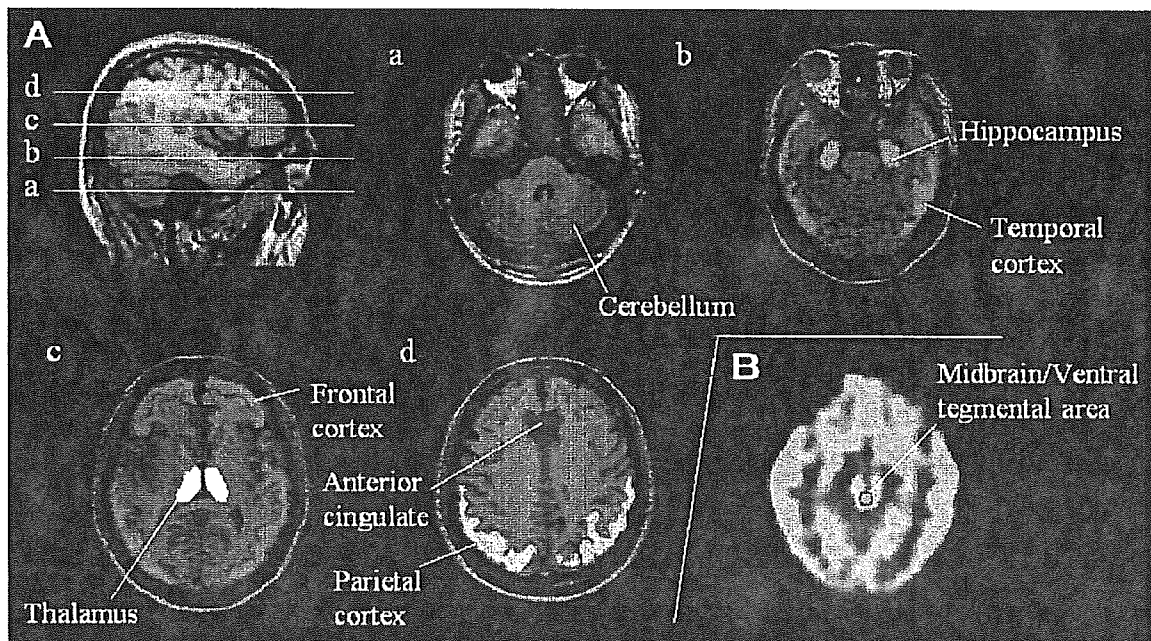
(a) The transformed VOI template placed on the axial slices of an MRI of one subject after refining to a segmented gray matter image. The horizontal lines through the sagittal section indicate the point of intersection for each of the corresponding axial sections. (b) The manually delineated circular ROI overlying the midbrain area containing the raphe nuclei in the axial plane of summated PET images of one subject.
